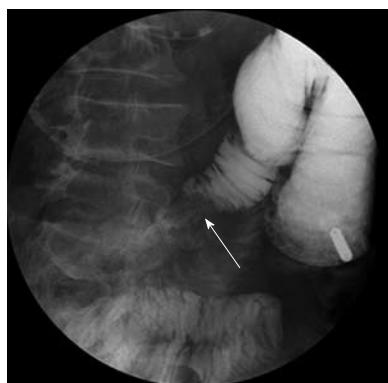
Diagnostic radiographic enteroclysis. Gastroenterography displayed on the 5th day of ileus tube decompression in a patient with postoperative adhesive small bowel obstruction. The tip of the tube had reached to the distal jejunum. After the anterior balloon was inflated with gas, angiografin was injected into the tube for gastrointestinal imaging to locate the lesion or stenosis in the bowel. Stenosis was found (arrow) in the small intestine with a filling defect, but none was developed in the distal bowel.
